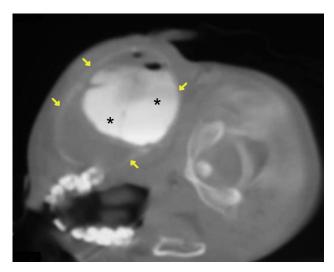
Axial CT image showing the ABC boundaries (arrows) and the injection of mixture of bone particles, autologous bone marrow, and nonionic contrast medium (asterisks) into the larger cyst cavities just after needle withdrawal.
